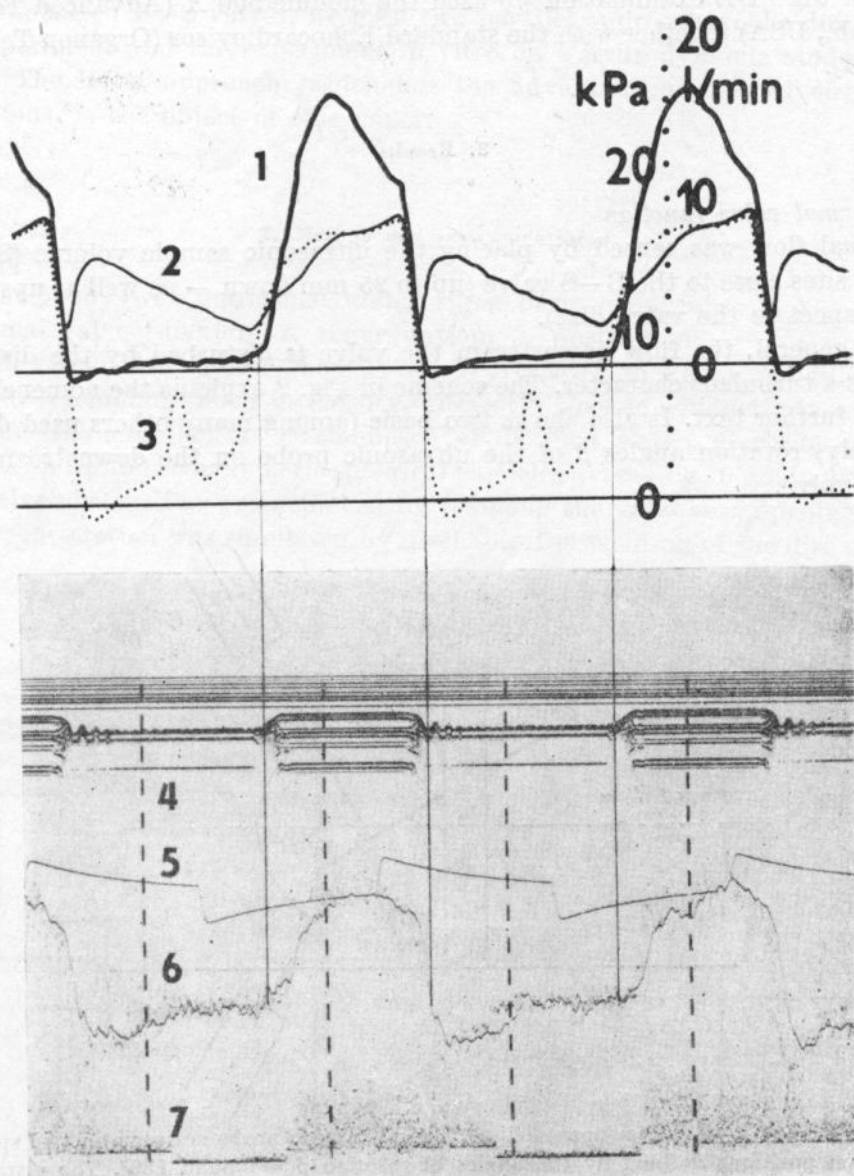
Normal valve function. SV in the minor channel approximately 3 mm downstream the valve ring and 5 mm from the tube wall (i.e. $\beta = 0^\circ$). 1 — flow sensed electromagnetically, 2 — “systemic” pressure, i.e. downstream the valve, 3 — pressure in the pump ventricle, i.e. upstream the valve, 4 — M-mode record of the valve disc action (with numerous reverberations), 5 — pump control pulses, 6 — local flow velocity sensed by the PDE system (solid line = wave of spatial average velocity within SV, dots: their scattering gives a qualitative knowledge about the width of Doppler signal frequency spectrum — this facilitates identification of the turbulence induced spectral broadening), 7 — instantaneous power of the Doppler signal (used mostly only for optimal setting of the pulsed Doppler device)
